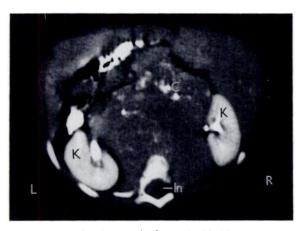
Computed tomography of abdomen of a 9-month-old girl who has neuroblastoma. Large retroperitoneal midline mass is displacing both kidneys (K) laterally, and hollow viscera are displaced anteriorly and laterally. Tumor has many discrete areas of dense calcification (C) and is invading right side of spinal canal (In).
